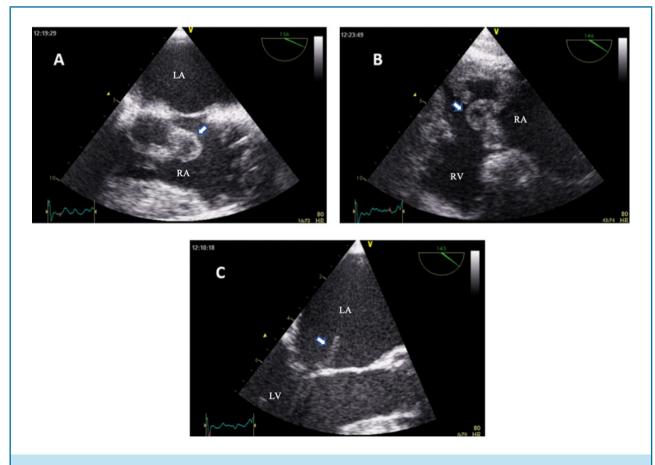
Transesophageal echocardiography showing large vegetations (arrows). *LA: left atrium; RA: right atrium; LV: left ventricle.*
